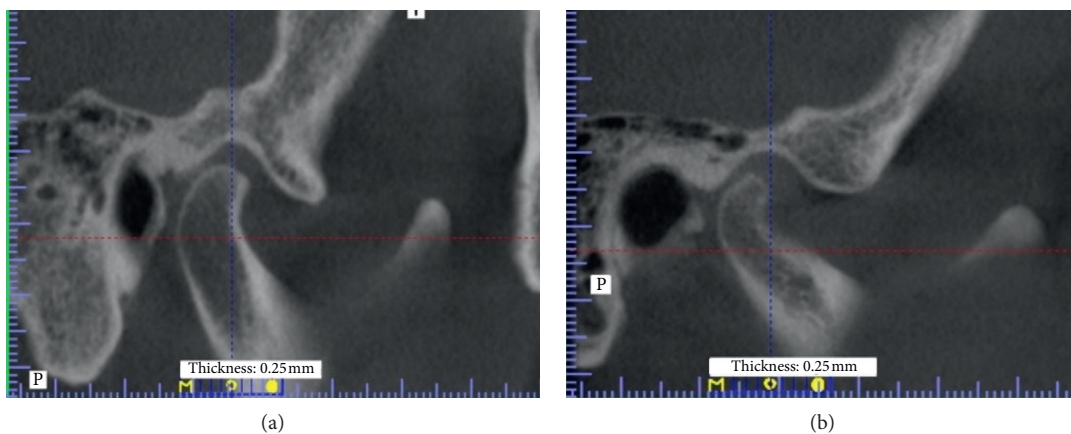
CBCT image of the topography of temporomandibular joint of the patients with tinnitus during the course of dysfunction: (a) 58-year-old female patient; (b) 68-year-old female patient.
